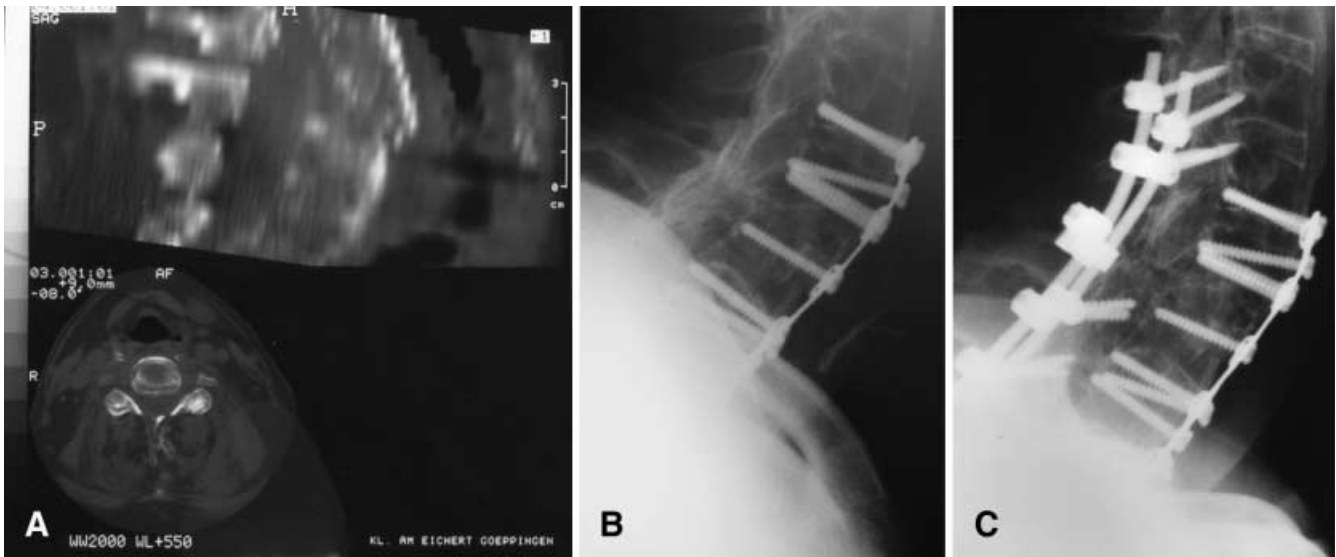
Fracture of C6/7 with Bechterew's disease: A lateral reconstruction on a computed tomography (CT) scan, B primary anterior fixation with a flexible implant with postoperative application of a cervical support, C additional posterior fixation with the Cervifix in the second stage
